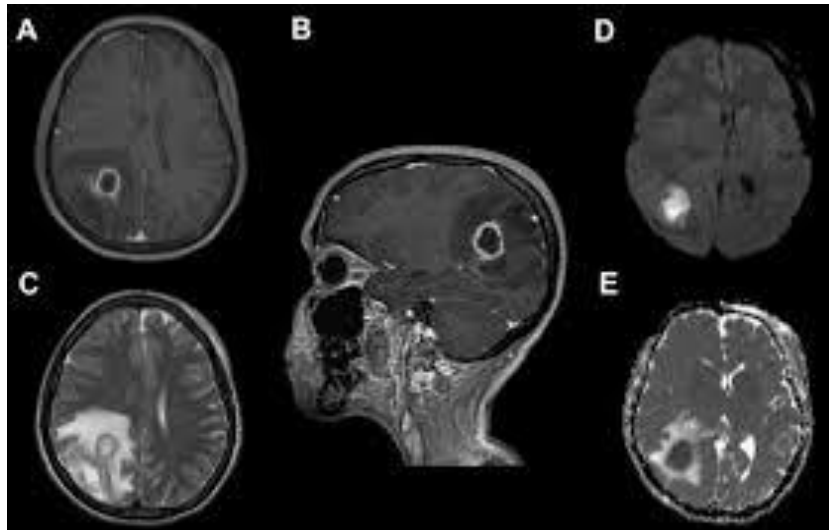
Brain abscess in the right parietal lobe. A and B. T1-weighted image axial and sagittal with intravenous contrast medium contrast, the abscess shows ring enhancement. C. T2-weighted image the abscess mixed intensity (from low to high) with peri- lesion edema. D. on DWI, the brain abscess high signal and edema low signal. E. the ADC shows the brain abscess low signal and edema high signal.
